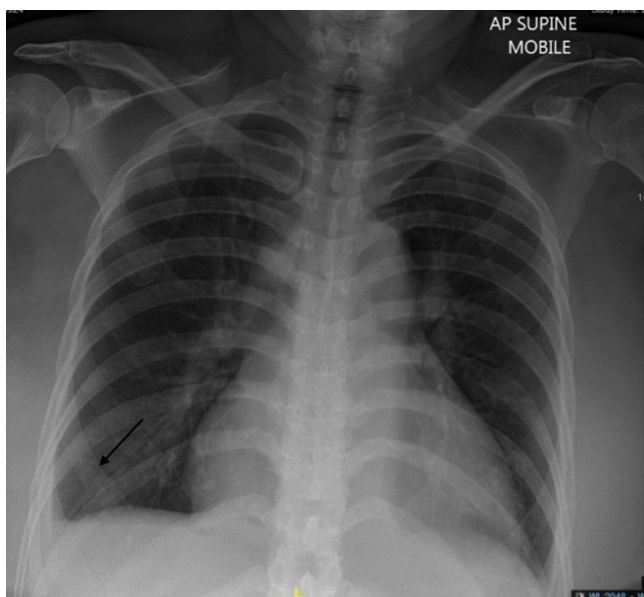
Chest radiograph taken on day of admission showed cardiomegaly with blunted right costophrenic angle (black arrow) and minimal right pleural effusion.
